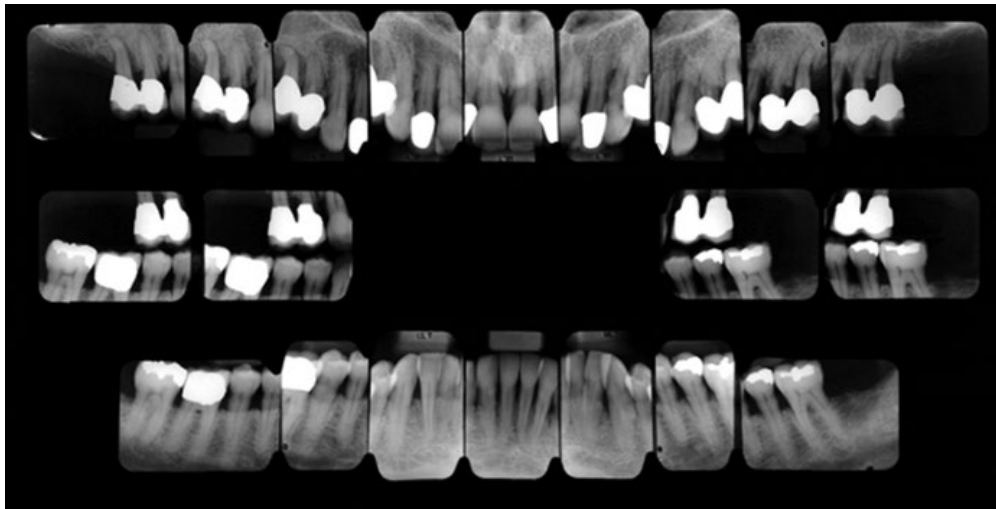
(A) Radiographs of a patient with severe periodontal disease and terminal posterior teeth and significant horizontal bone loss and mobility.
